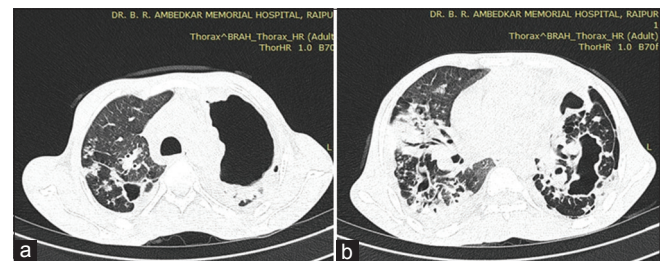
Axial high-resolution computed tomography image at the level of (a) arch of aorta showing multiple centrilobular nodules with clustering and tree-in-bud pattern at some places. Thick-walled cavitory lesion is also seen at the left upper lobe. (b) Airspace consolidation with irregular cavitory lesion noted involving bilateral lower lobes. Case of culture-positive pulmonary tuberculosis
